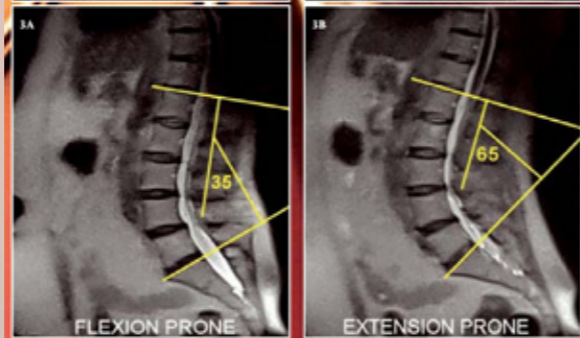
HASTE images showing COBB angles for an asymptomatic male volunteer undergoing (A) flexion and (B) extension lumbar spine MRI (range of motion 50°).
